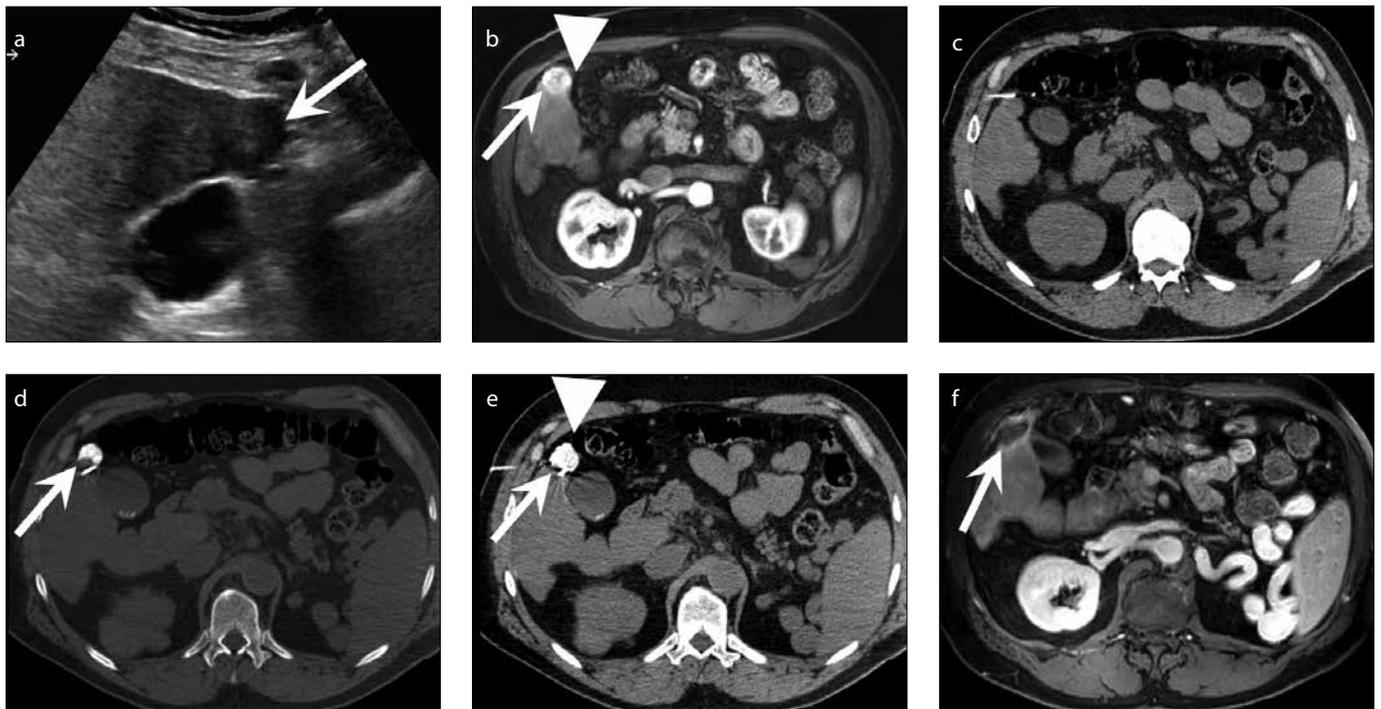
a–f. Ultrasound image (a) demonstrates a hypoechoic mass (arrow) within segment 5 of the liver. Contrast-enhanced MRI (b) shows an avidly enhancing mass within segment 5 of the liver anteriorly (arrow). The transverse colon is noted to abut the liver mass with essentially no free interface between the colon and the liver (arrowhead). Panels (c–e) show a needle inserted just anterior to the liver mass in order to inject contrast-loaded fibrillar collagen and displace the colon away from the mass (arrow). There is a much wider interface between the mass (e, arrow) and the colon (e, arrowhead). Follow-up contrast-enhanced MRI (f) of the mass after ablation (arrow) demonstrates complete devascularization of the mass without injury to adjacent structure.
